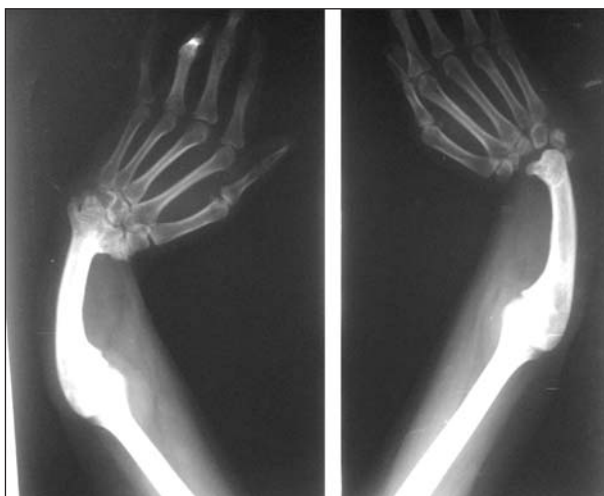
X-ray of the patient showing bilateral absence of radii.
